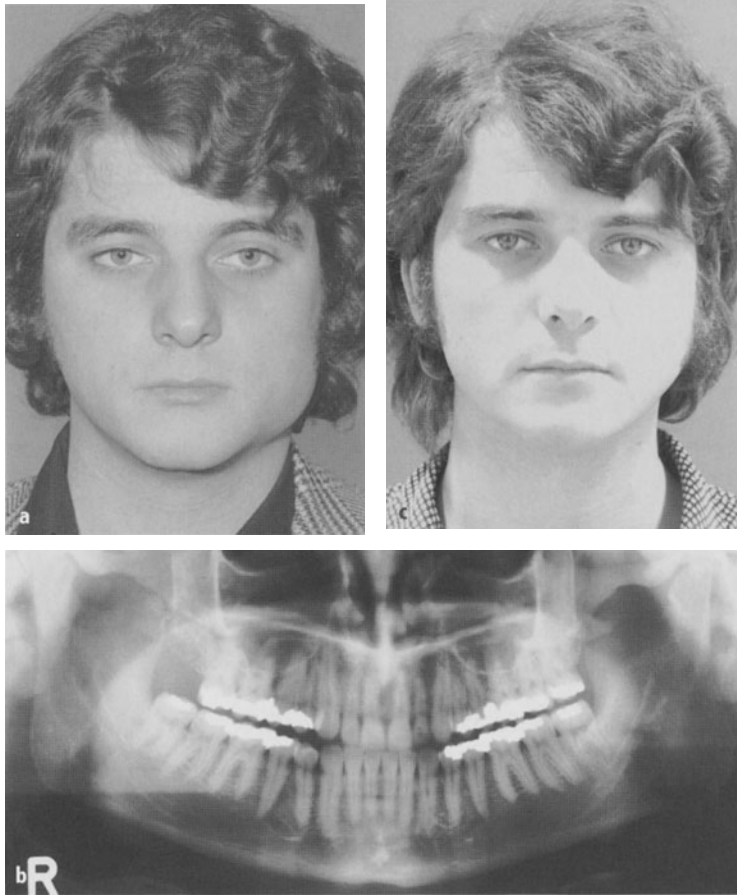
Unilateral pseudo H.H. due to unilateral masseter hypertrophy. a The patient's front view discloses a marked swelling in the left angle area. b On the panoramic radiograph the mandible seems very strong but symmetrical, except for the very prominent and deformed left angle. Both coronoid processes look very short and obtuse. c The patient's appearance 18 months after surgery
